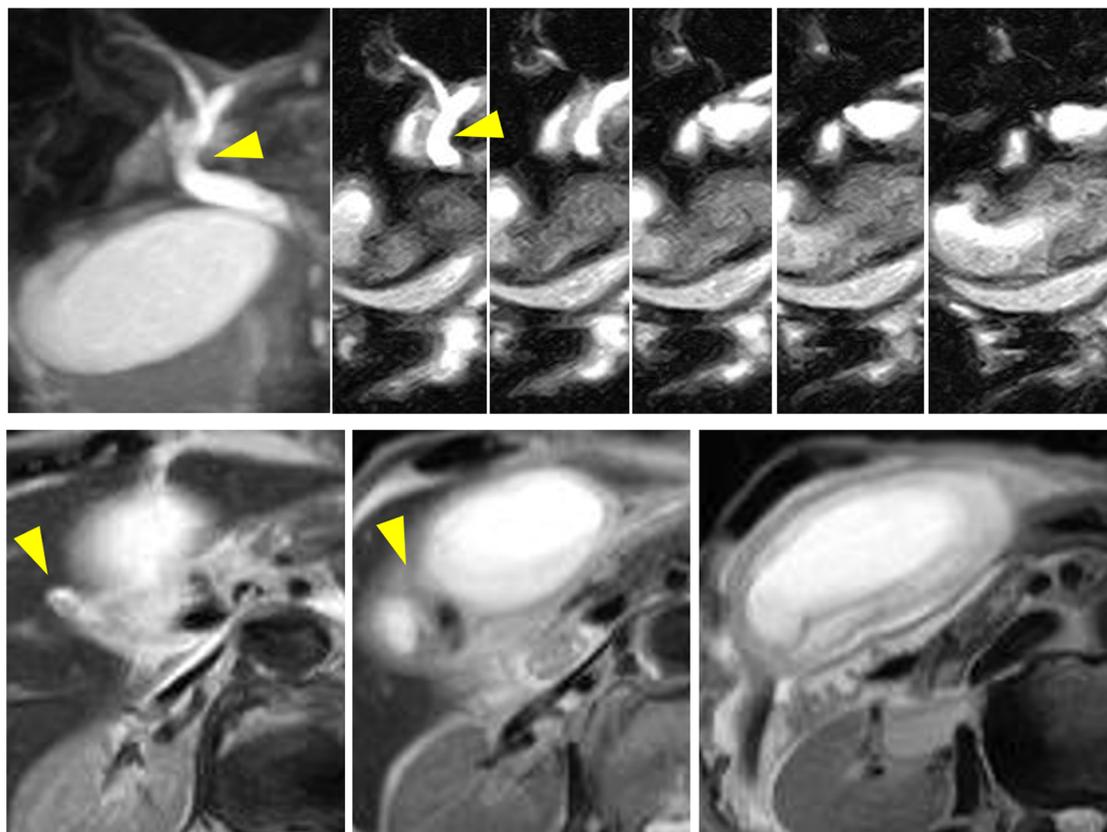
MRC and T2-weighted MR findings; MRC images showing tapering of the cystic duct and interruption (arrow) and he extrahepatic bile duct exhibits a V-shaped distortion (arrow head, upper series), and MR images showing thickening of the gallbladder wall and pericystic fluid collection (lower series)
